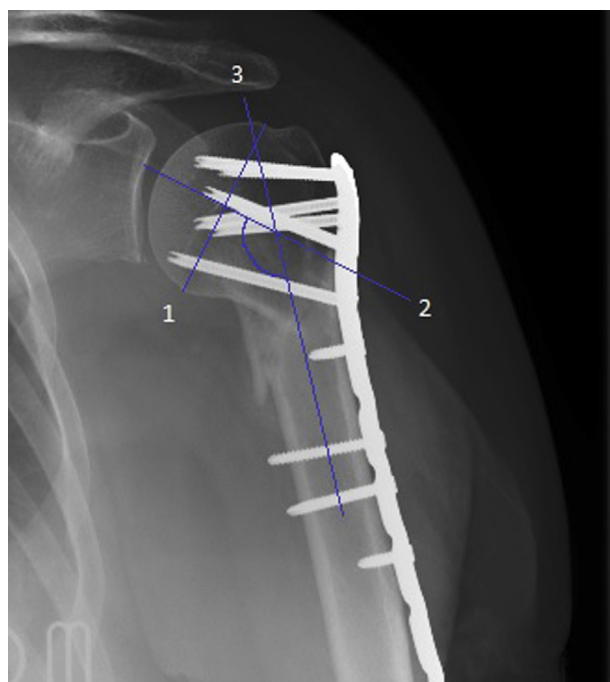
Radiograph depicting the humeral head-shaft angle. Line 1 is the anatomic neck; line 2 is perpendicular to the anatomic neck coincident with line 3 bisecting the humeral shaft. The angle subtended between lines 2 and 3 represents the head-shaft angle.
